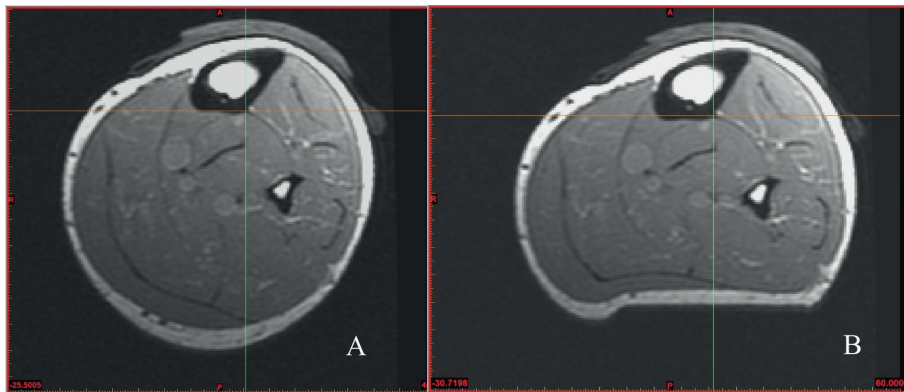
MR images of non-loaded (A) and loaded (B) conditions at the slice of indenter apex. The visible y and x axes intersect at the centre, the origo, of the defined local coordinate system.
